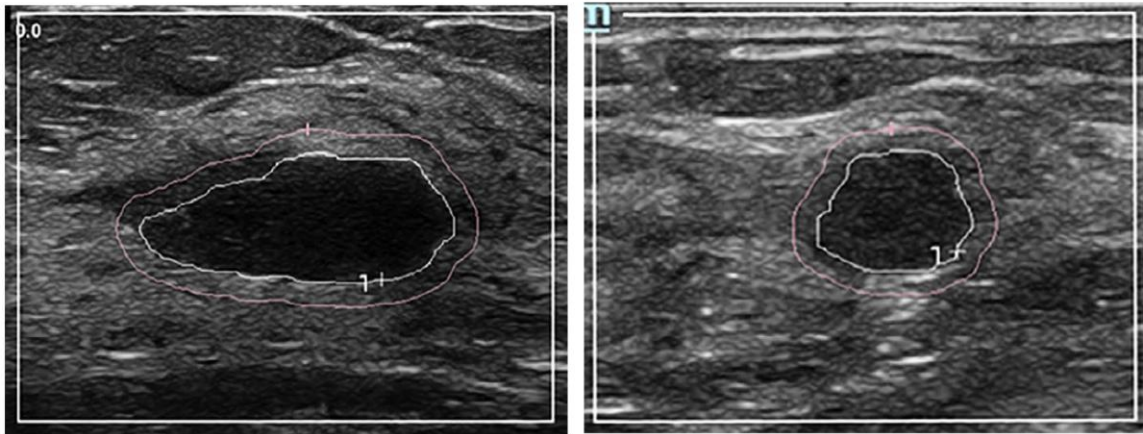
ELASTOSONOGRAPHY DEPECTING “STIFF RIM” SIGN IN PERITUMORAL REGION
